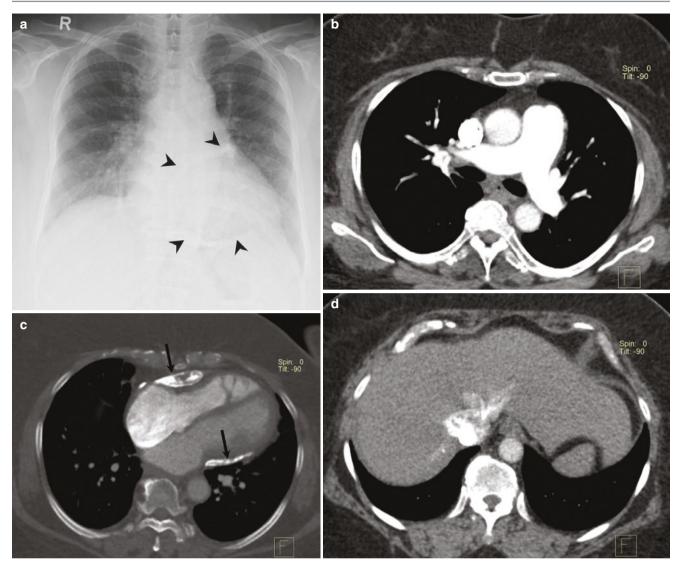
A 49-year-old woman with PAH from calcific constrictive pericarditis. (a) Frontal chest radiograph shows curvilinear calcification along the pericardium (arrowheads). (b) Axial CTPA image shows dilated
